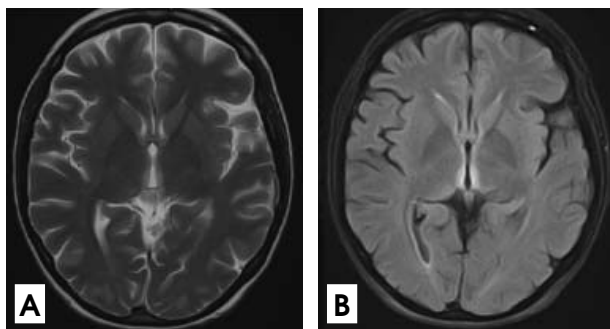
Symmetrical high intensity in bilateral paramedian thalamic nuclei on non-enhancing T2 (A) and fluid-attenuated inversion recovery (FLAIR) (B) sequence images
